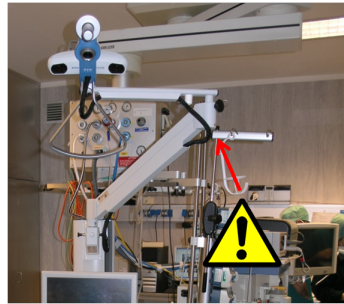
Example of warning sign in housing of intraoperative device (arrow). Arm of CSS300 (implementation of freehand SPECT technology by spin-off company SurgicEye) is too low and can be a danger to users. Accordingly a warning has to be added to it.
